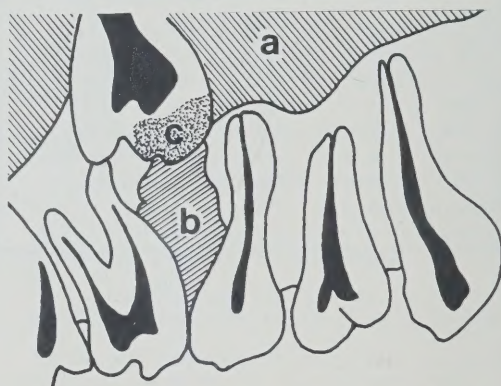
Sketch from periapical X-ray showing relationship of impacted crown to sinus and adjacent roots. (a) Maxillary sinus. (b) Periodontal pocket. (c) Decayed portion of crown.
